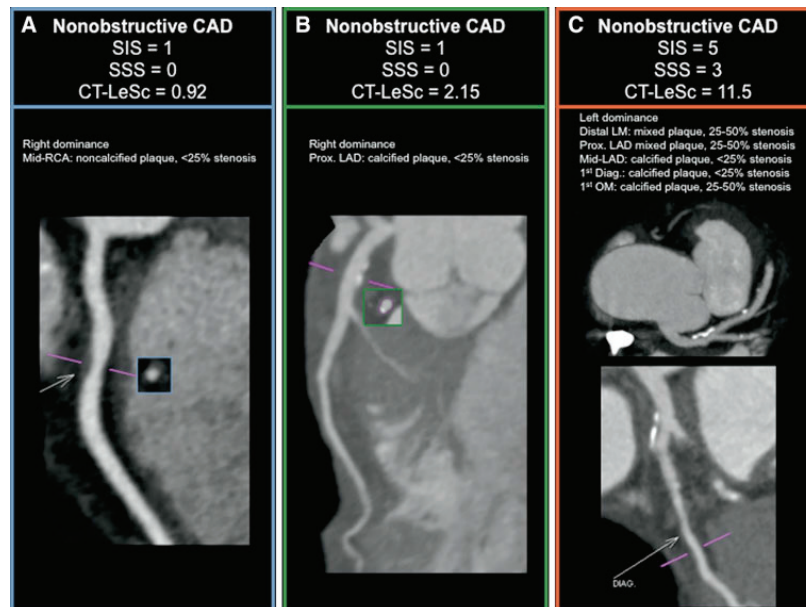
Three cases examples of patients with nonobstructive CAD stratified by different coronary atherosclerotic burden scores. In panel A, a patient with a single lesion in the mid-RCA (weighting for localization \times type of plaque \times stenosis severity = $1 \times 1.5 \times 0.615 = 0.92$); In panel B, a patient with a single proximal LAD lesion (CT-LeSc = $3.5 \times 1 \times 0.615 = 2.15$). In panel C, a patient with left dominance and 5 nonobstructive lesions with a total
